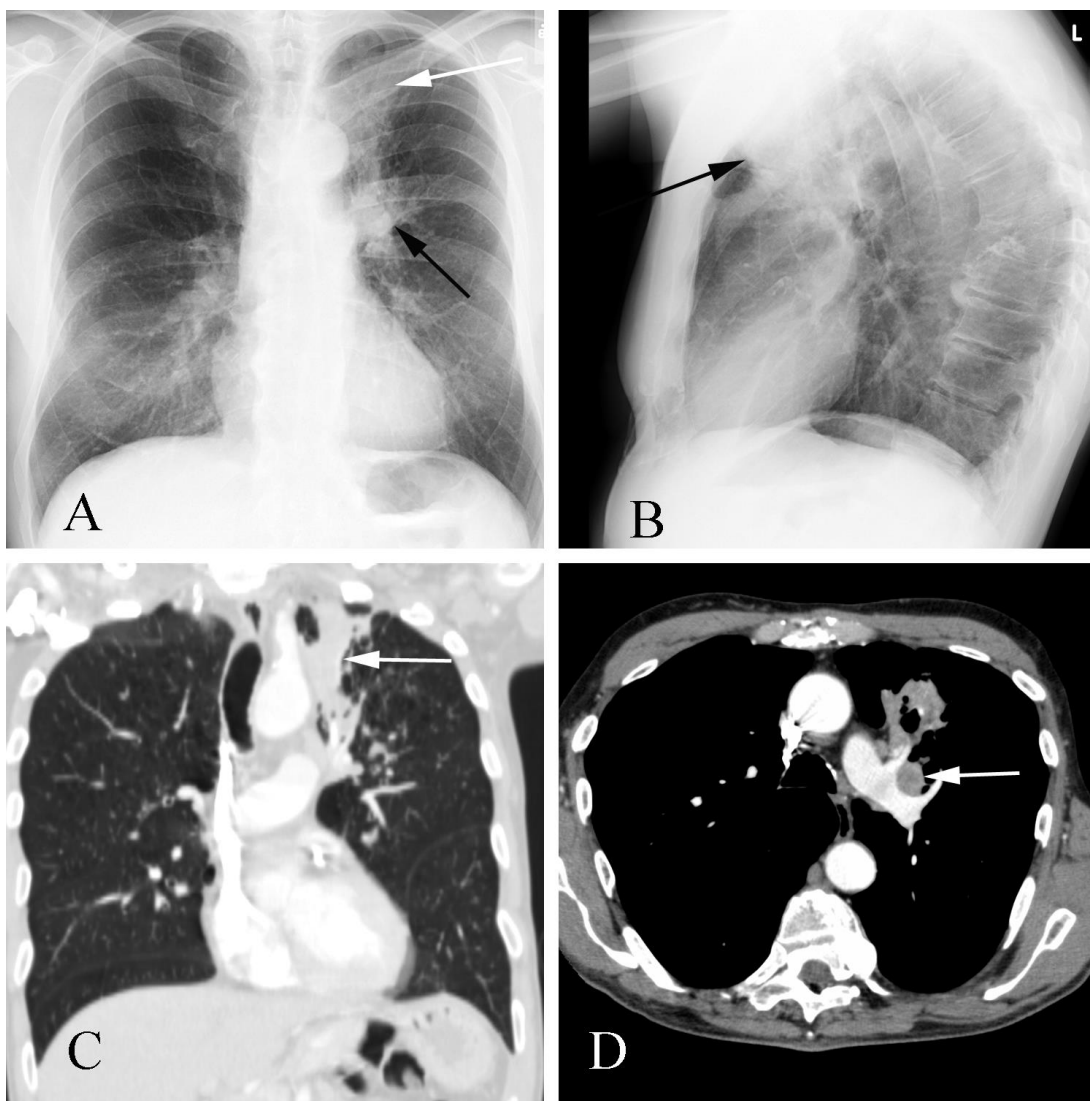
Lung cancer in a 68 year old man with hemoptysis. A. PA chest shows consolidation of the left upper lobe (white arrow) and left hilar fullness (black arrow). B. Lateral exam confirms abnormal opacity in the so-called “anterior clear space”, anterior to the trachea. C. Coronal reformatted CT shows the area of consolidation in the left upper lobe corresponding to the plain film findings. D. Axial CT shows lymphadenopathy along the left pulmonary artery (white arrow) as well as lung consolidation. Lung cancer was subsequently diagnosed.
